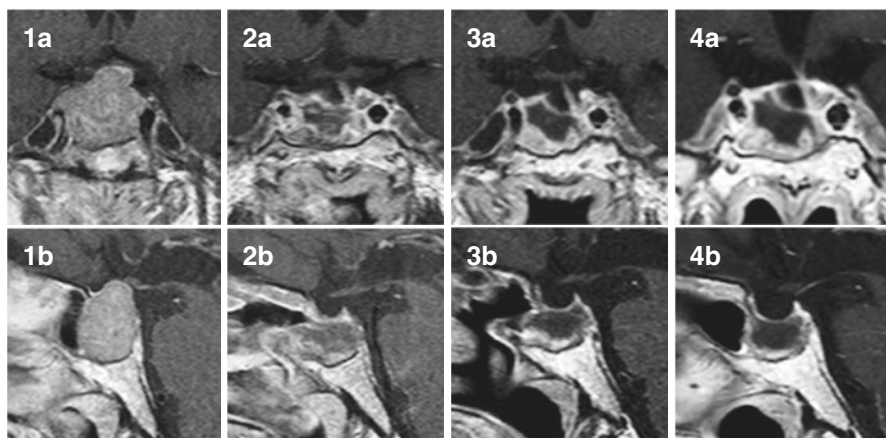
(1a) Coronal and (1b) axial preoperative T1-weighted gadolinium contrast-enhanced MR image; (2a) coronal and (2b) axial postoperative T1-weighted gadolinium contrast-enhanced MR image; (3a) coronal and (3b) axial post-RT T1-weighted gadolinium contrast-enhanced MR image; (4a) coronal and (4b) axial T1-weighted gadolinium contrast-enhanced MR images at last follow-up
